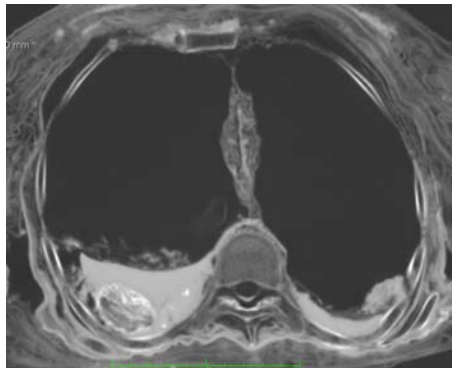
CT scan of the chest of RM2718, showing the heart intact in the pericardial sac, despite removal of the lungs and other organs.
